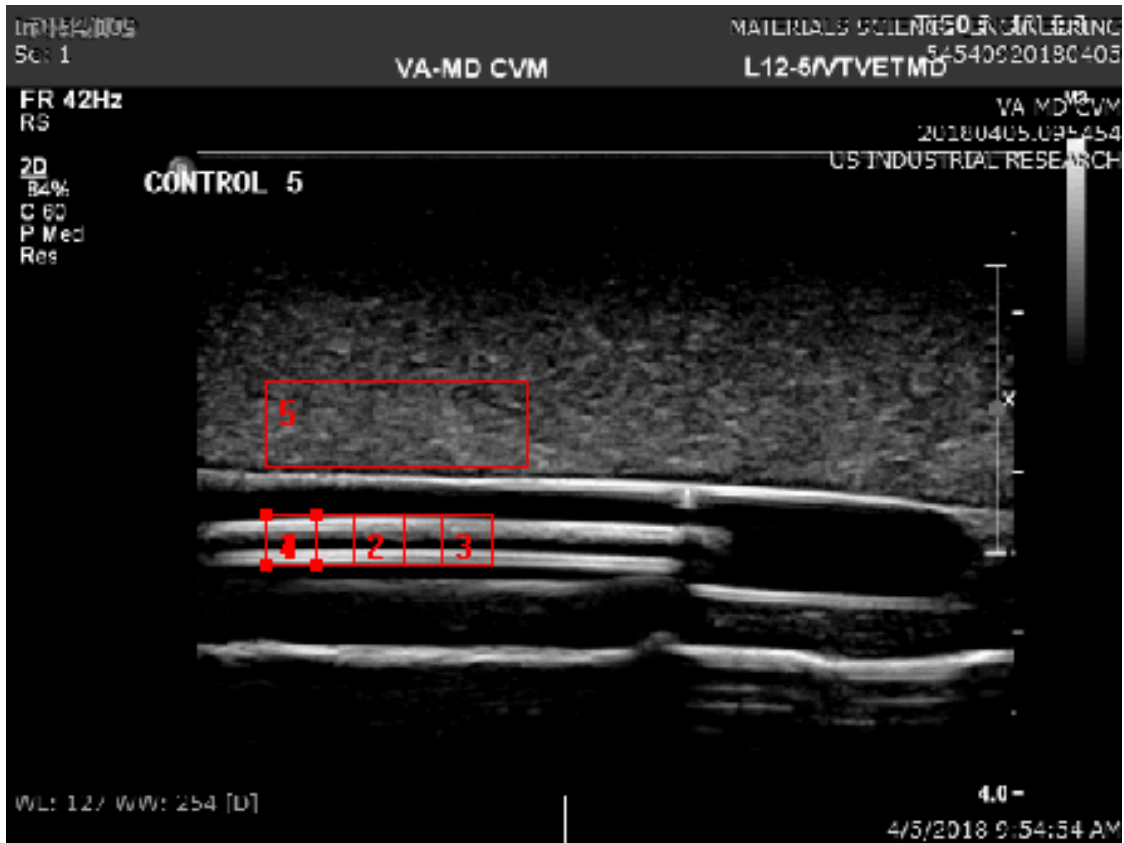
Example ultrasound image under B-mode, showing the regions of interests defined in the Andor Solis program. Three regions of interests (1, 2, 3) were used for Signal to Noise analysis.
